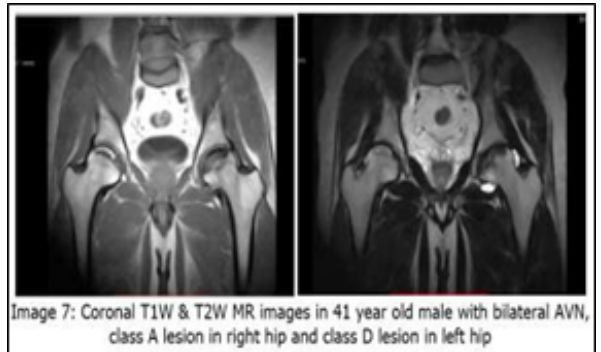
Coronal T1W & T2W MR images in 41 year old male with bilateral AVN, class A lesion in right hip and class D lesion in left hip
